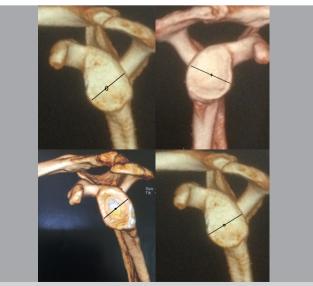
Measurement of the distances on the computed tomography.
